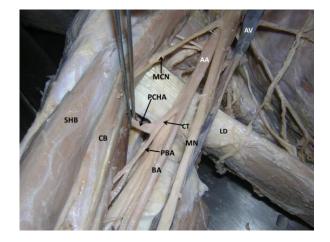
Dissection of the right axilla and proximal part of the arm showing the common trunk (CT) of profunda brachii artery (PBA) and posterior circumflex humeral artery (PCHA)) (AA – axillary artery; AV – axillary vein; MCN – musculocutaneous nerve; MN – median nerve; LD – latissimus dorsi; CB – coracobrachialis; SHB – short head of biceps; BA – brachial artery).
